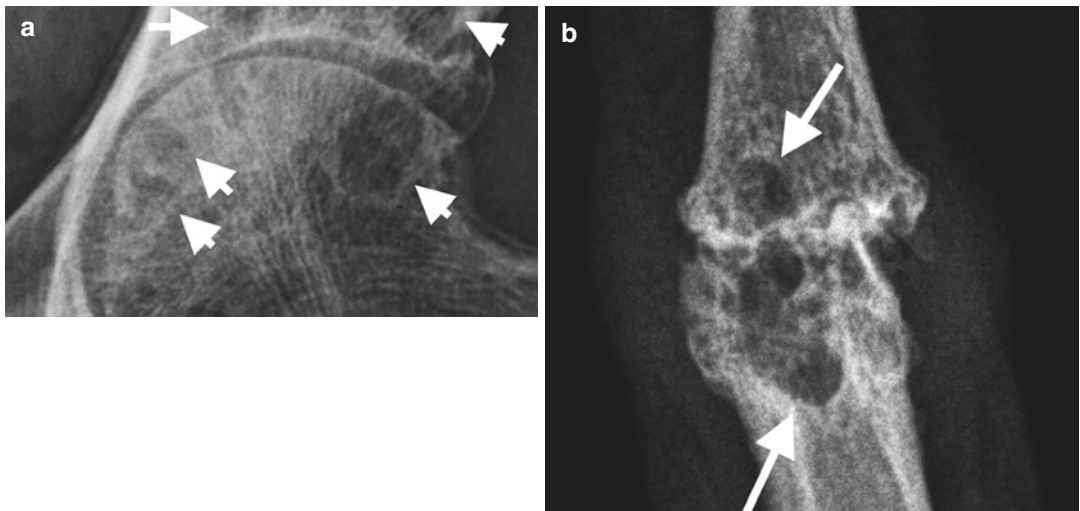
Eburnation (*arrows*) on radiograph, (a) magnified AP subchondral region hip joint demonstrating increased subchondral sclerosis on both sides joint, (b)
